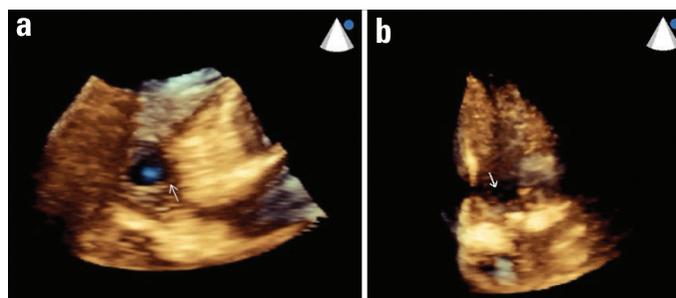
(a) The cross-section of three-dimensional echocardiography view of the pseudoaneurysm (arrow) from the pulmonary arterial perspective. (b) The longitudinal section of the pulmonary artery and the orifice of the pseudoaneurysm (arrow)
